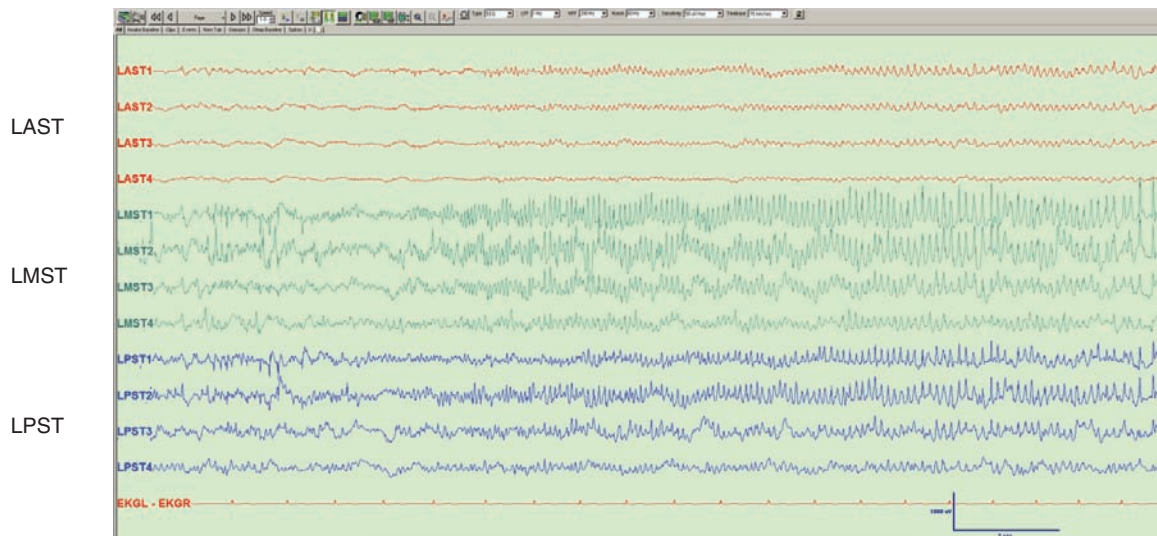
Electrographic and clinical seizures from an adult patient with intractable seizures, nonlesional imaging, with electrodes implanted over the left temporal region. (A) Lateral skull x-ray showing implanted electrodes. An 8 × 8 grid (LTG) was implanted over the lateral temporal region. Three 1 × 4 strips (LAST, LMST and LPST) were implanted over the left subtemporal region (anterior to posterior). (B–D) Habitual clinical seizure (clinical onset at vertical line in B) showing onset with rhythmic 3–4 Hz sharp waves at LAST2–4 and LTG26, 32, and 42. (E–G) Electrographic only seizure starting at LMST1–3, LPST1–4, with rapid spread to LAST1–4. Patient had extensive resection of anterior and inferior temporal regions, including mesial structures, with resolution of her seizures.
